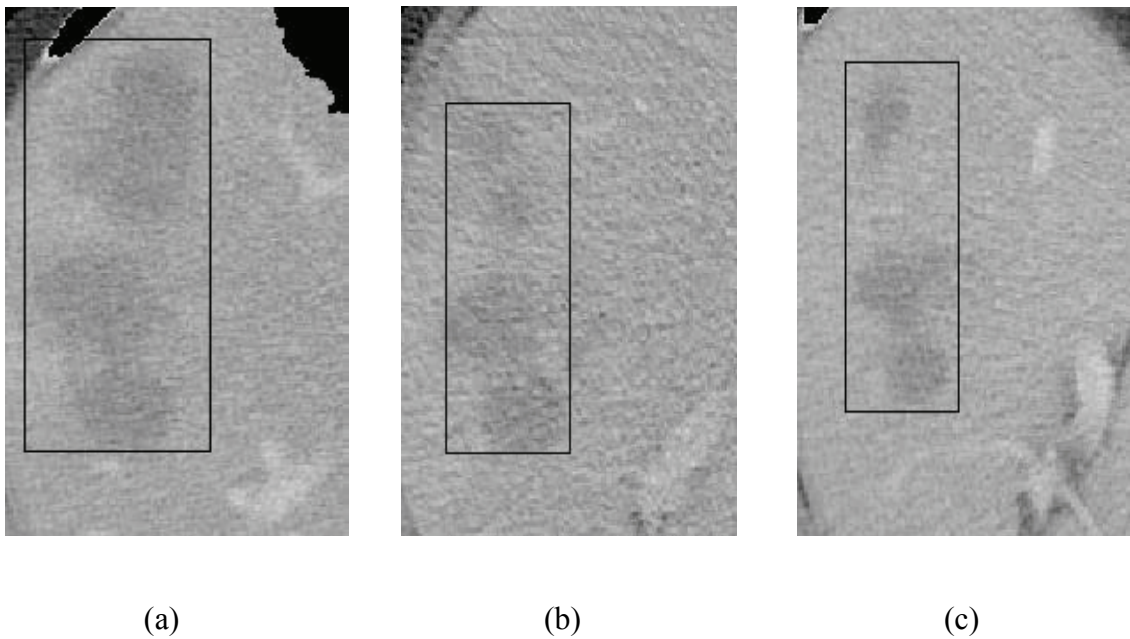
CT liver scans of patient showing tumor (a) baseline (b) after 1 month (c) after 5 months
